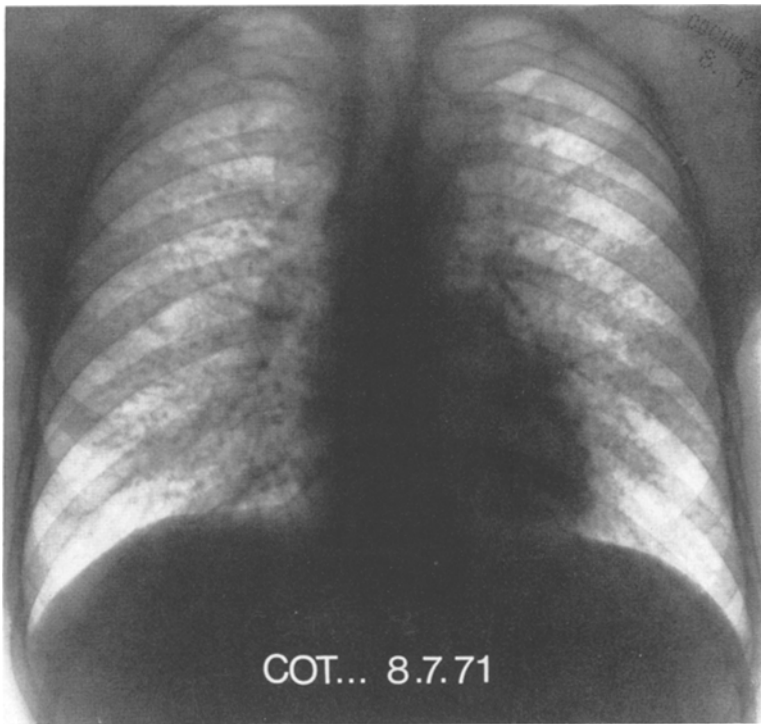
Chest radiograph taken a few days before biopsy
